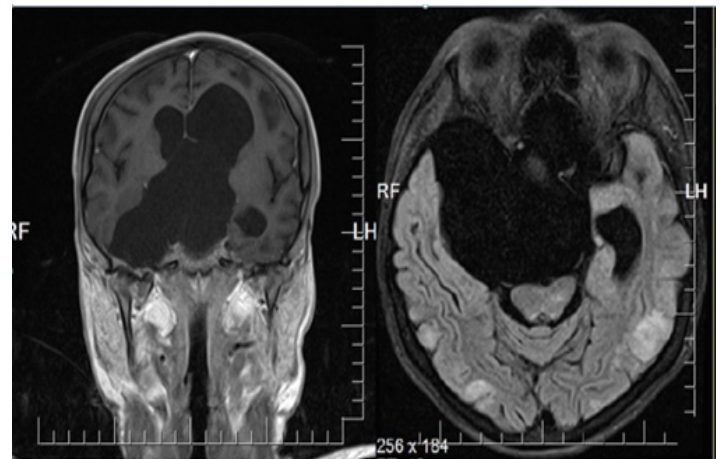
MRI of the brain of the patient B., 22 y. o. Occlusive triventricular hydrocephalus, giant cyst of the third ventricle, PRES syndrome.
